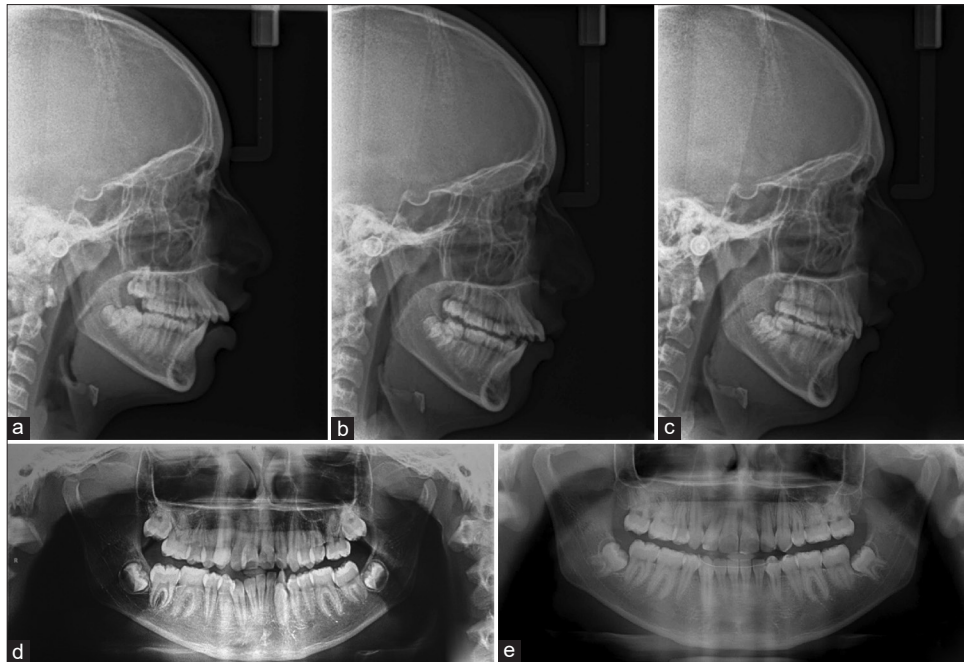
Pretreatment Lateral Cephalograms & Orthopantomogram (a & d), Mid-treatment Lateral Cephalogram (b) and Post-treatment Lateral Cephalograms & Orthopantomogram (c & e)
